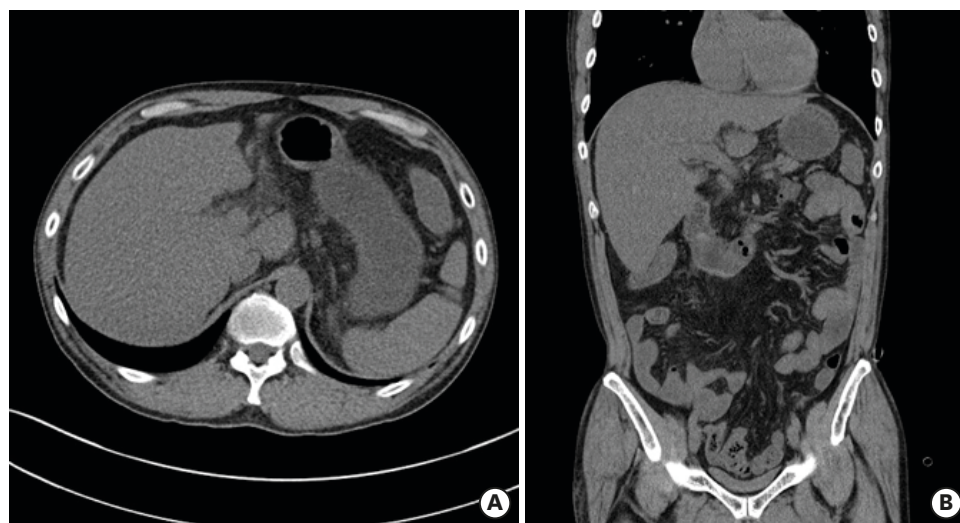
Axial (A) and sagittal (B) abdominal computed tomography imaging shows no nodular liver contour.
